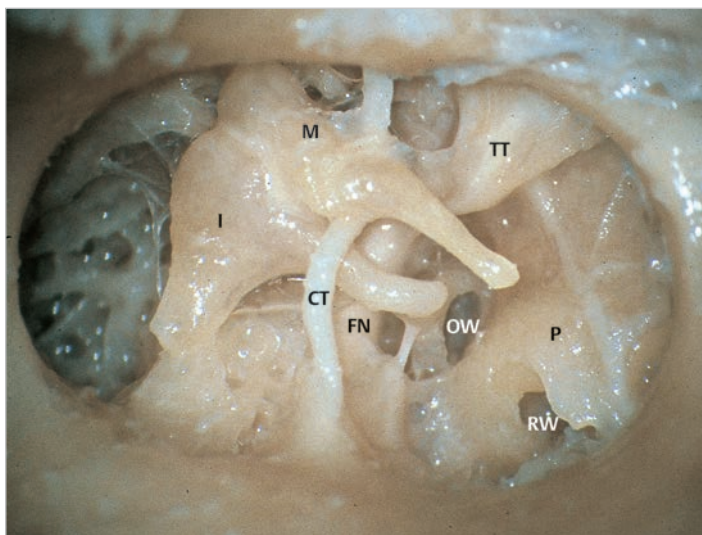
The structures in the right tympanic cavity are shown after performing atticotomy and partially removing the posterior canal wall. The bone is placed in the similar way to the surgery. Important structures in the medial wall of the middle ear are shown. CT, chorda tympani; FN, facial nerve; I, incus; M, malleus; OW, oval window; P, promontory; RW, round window niche; TT, tensor tympani.
